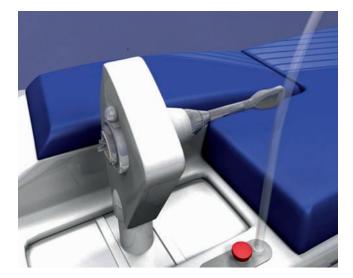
Fixation of the high-intensity focused ultrasound probe
